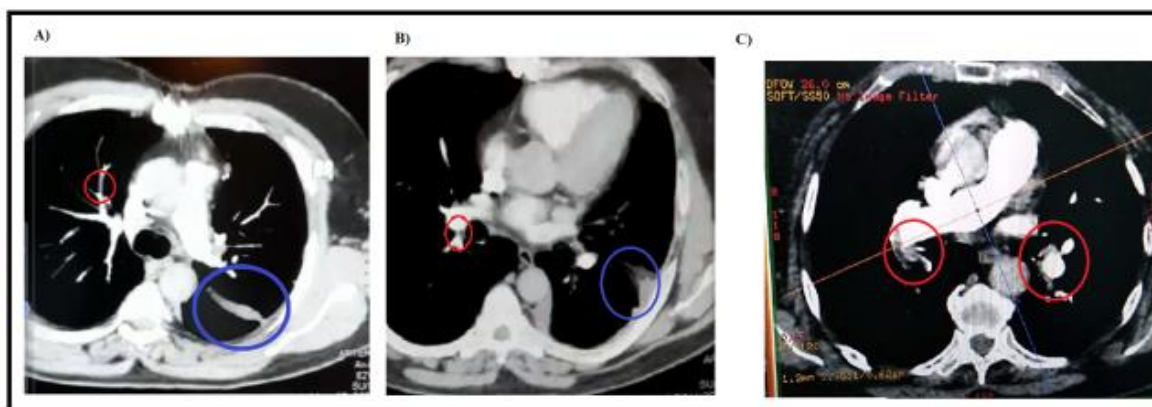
(A) Computerized tomography (CT) angiography (axial image) of COVID19 patients showing pulmonary embolism (red circle) accompanied with a linear band in the left lower lobe (blue circle), (B) CT scan shows a pulmonary embolism that affect the right artery and present a peripheral wedge-shaped area (blue circle) that may be resulted from a pulmonary embolism-induced lung infarction, (C) CT scan shows a pulmonary embolus that affects the right main pulmonary artery (red ring) and nonocclusive pulmonary embolism in the left pulmonary artery (blue circle)
